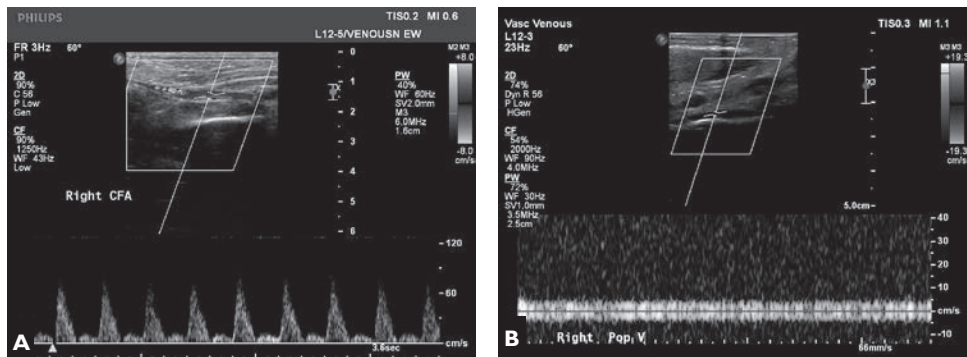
Colour Doppler ultrasound scan of right leg showed thrombosis of right common femoral vein (CFV) with unobstructed arterial flow on admission.
